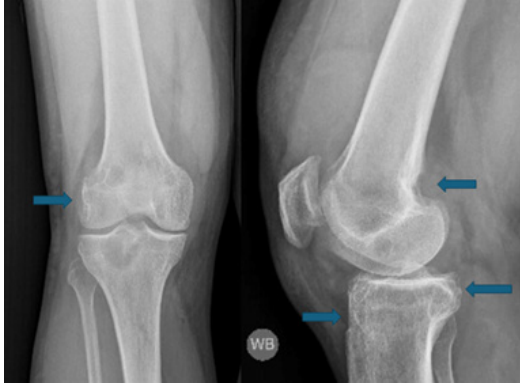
X-ray of right knee demonstrating pigmented villonodular synovitis. Anterior-Posterior (Left) and Lateral (Right) views demonstrating multiple erosions in the lateral femoral condyle and proximal tibia, large joint effusion, and degenerative changes.
